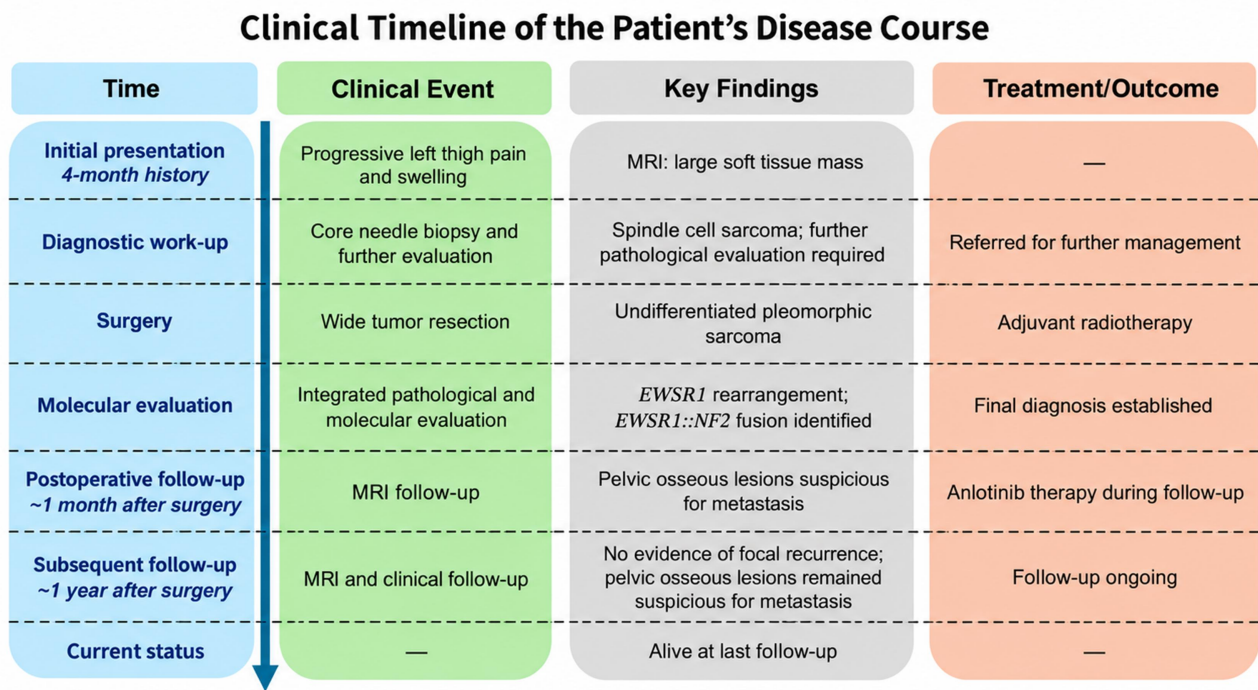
Clinical timeline of the patient's disease course. The timeline summarizes the major clinical events, diagnostic evaluation, treatment interventions, and follow-up information from initial presentation to the latest follow-up. MRI, magnetic resonance imaging.
